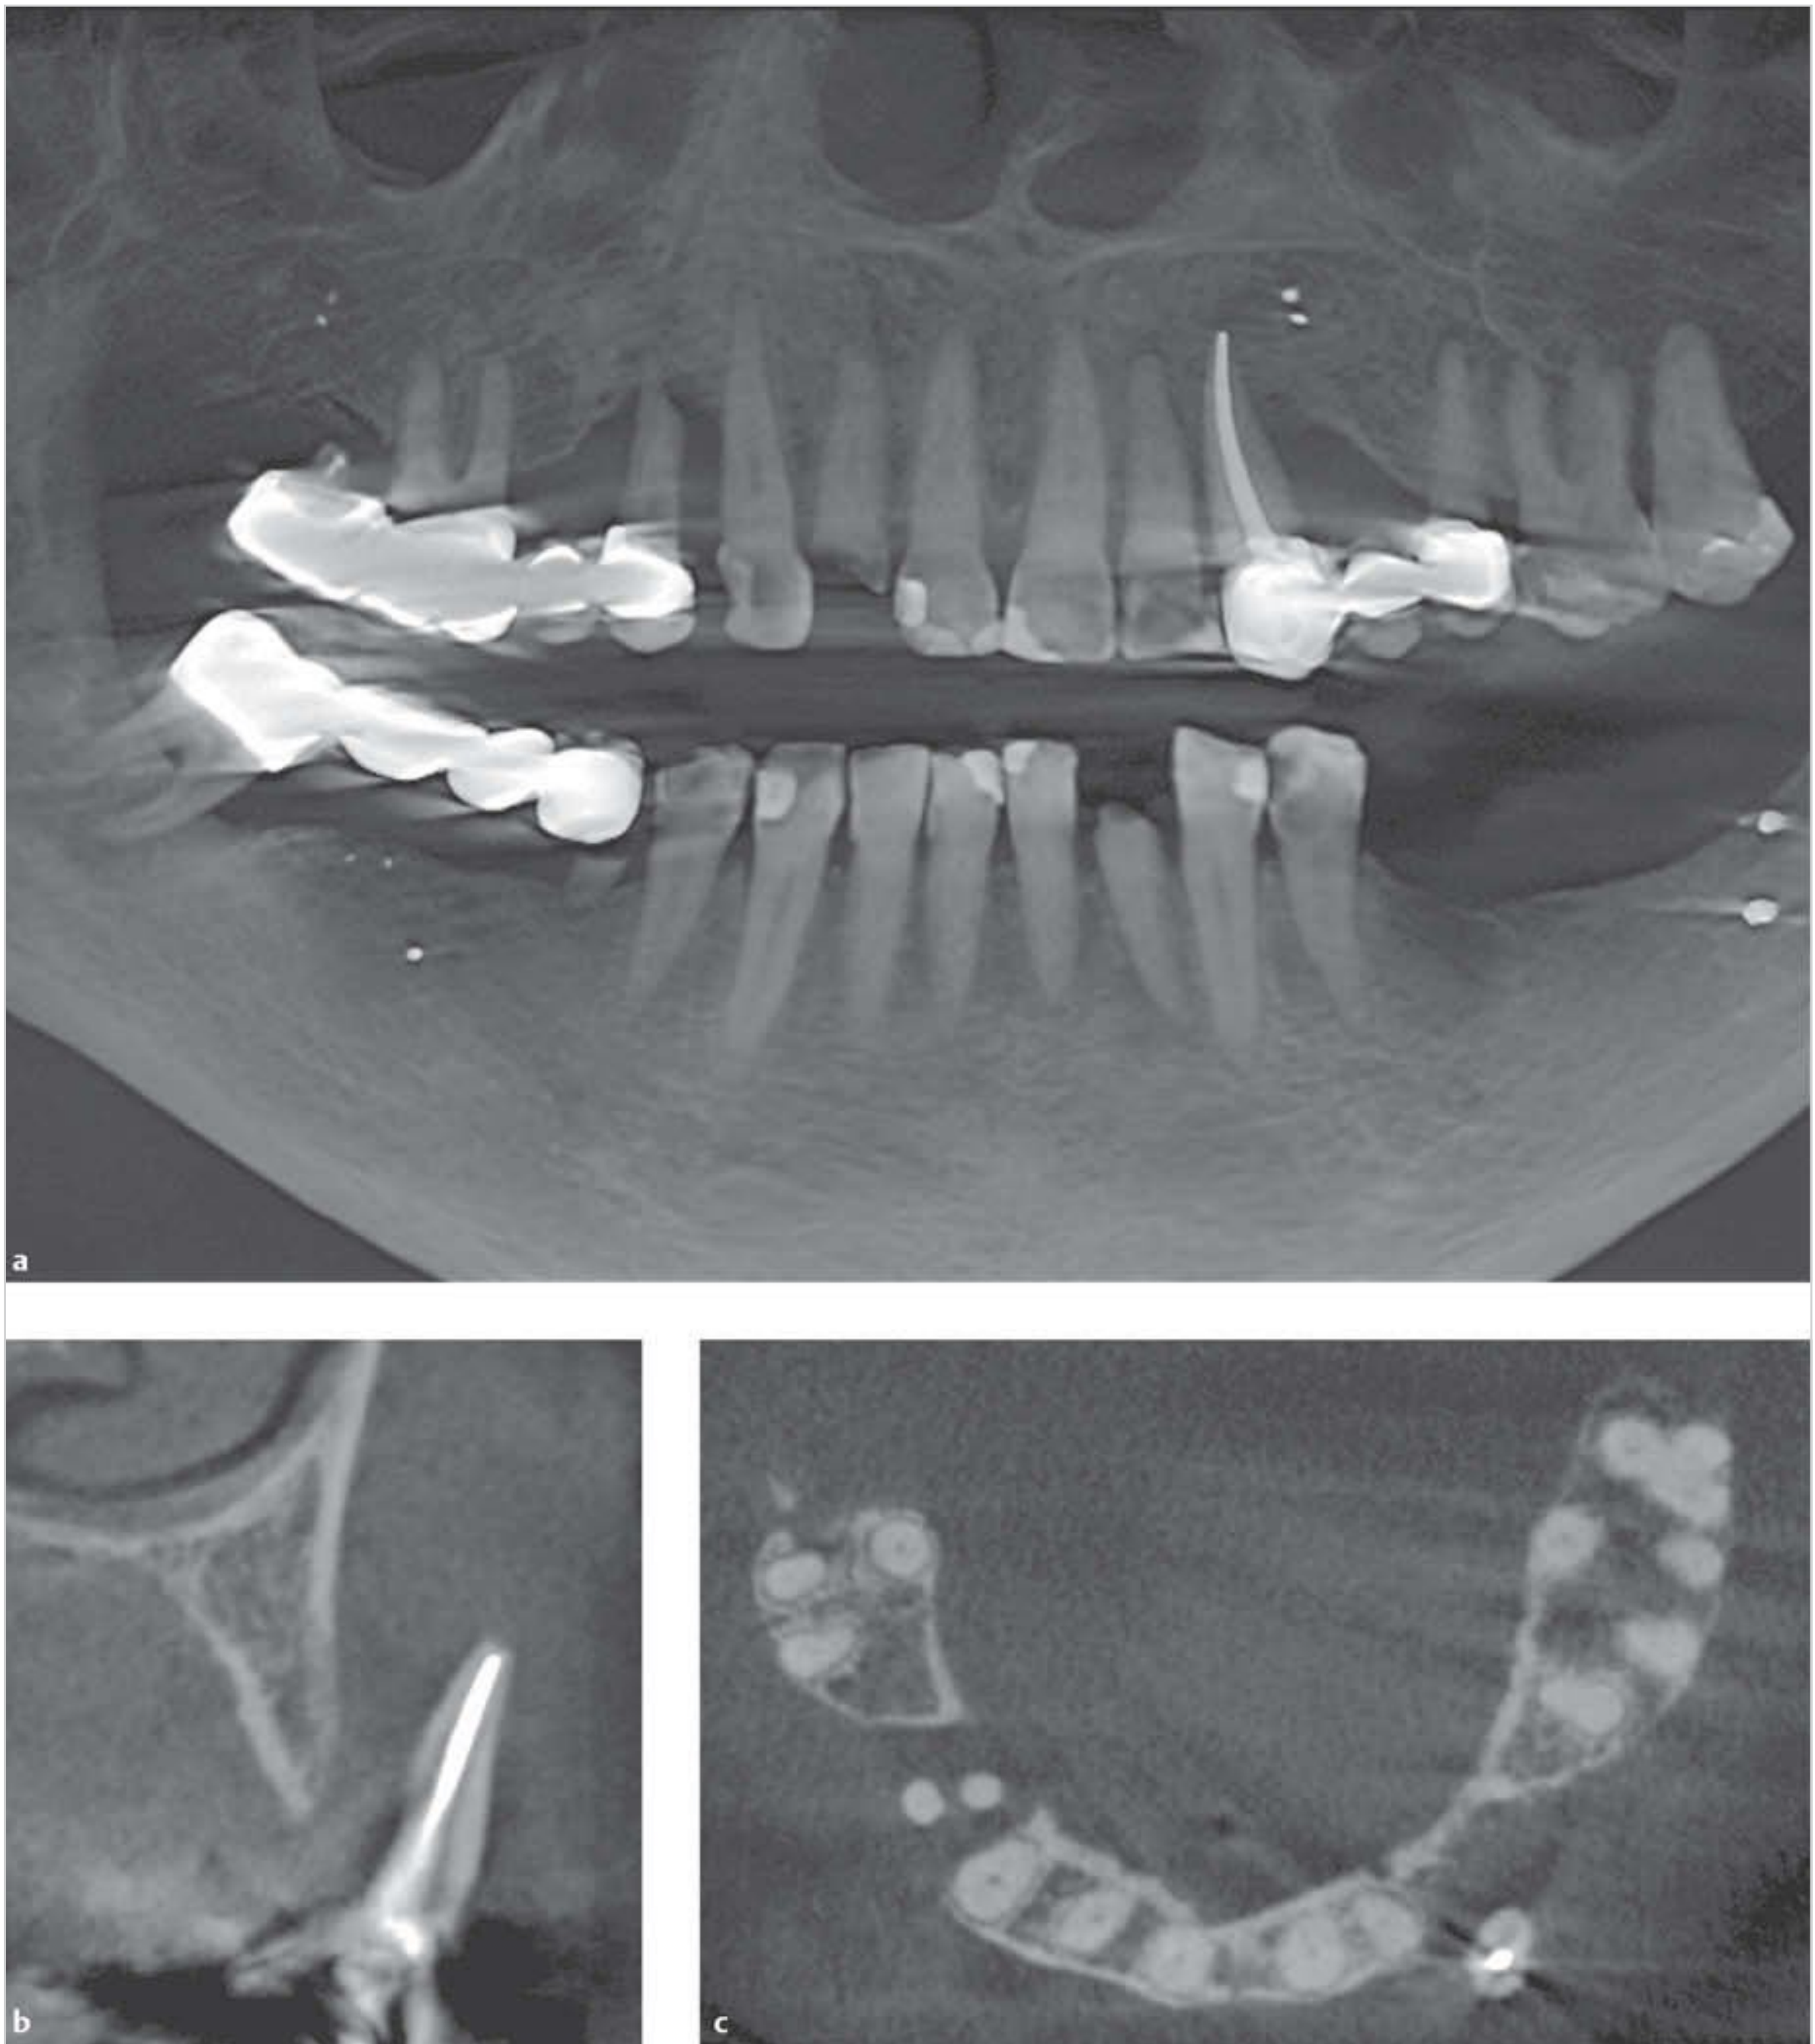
This panoramic radiograph (a) revealed deep vertical bone loss on the distal surface of tooth 22. Periapical radiographs did not show any abnormalities. Transverse (b) and axial (c) views were needed to demonstrate that a cyst was causing vestibular displacement of the endodontically treated tooth.
